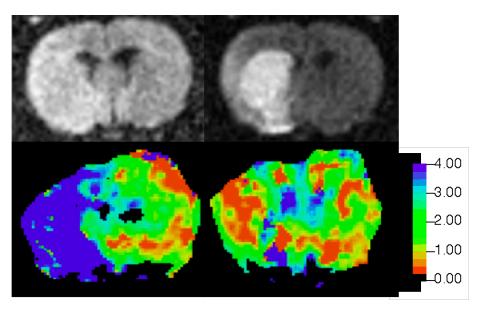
Occlusion and reperfusion of the right MCA territory. DWI images show a persistent hyperintensity in the right MCA territory during occlusion and 4h after reperfusion. PWI images show low perfusion in the right MCA territory during occlusion and almost complete reperfusion at 4h after removal of the filament.
